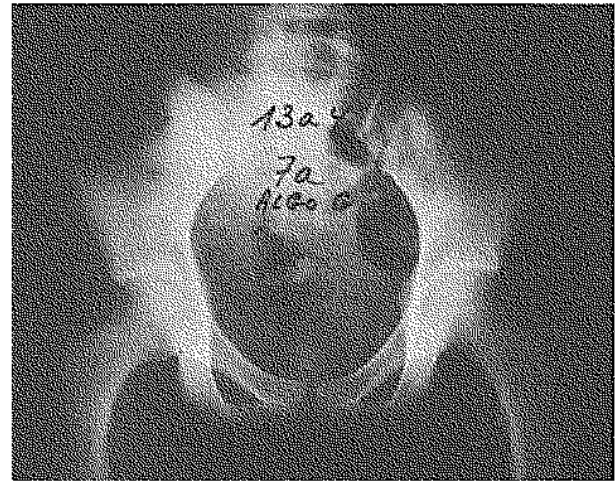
Anteroposterior radiograph of the hips of a 13-year-old girl, 7 years after the development of RSDS of the left hip. She developed a coxa magna on the left side.
